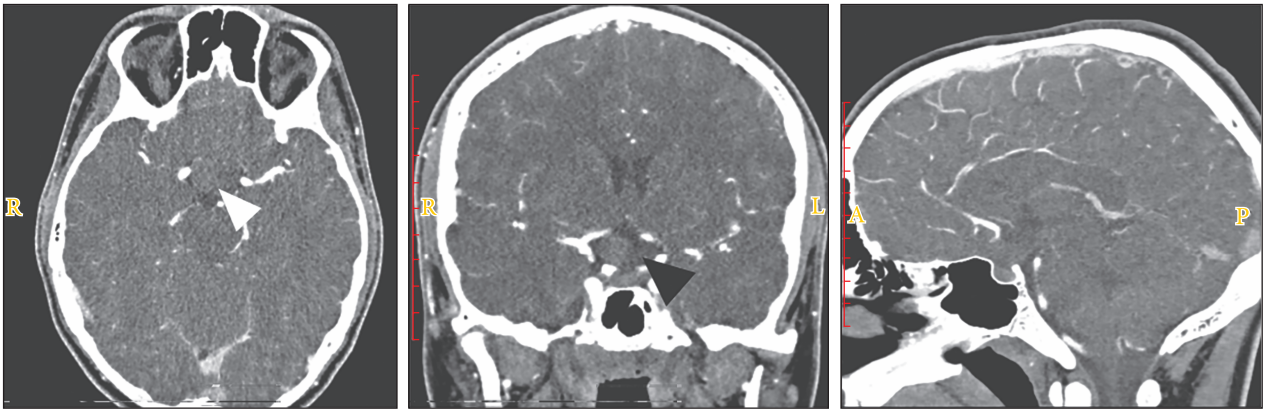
CT angiography shows a suprasellar lesion with a density of +49 to +59 Hounsfield units lateralized to the right (white and black arrowheads, respectively)
